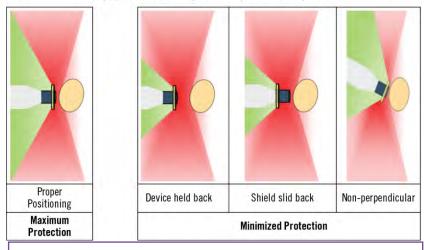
Example of manufacturer instructions on achieving maximum protection from x-rays through proper positioning of the handheld device. Image courtesy of KaVo Kerr
